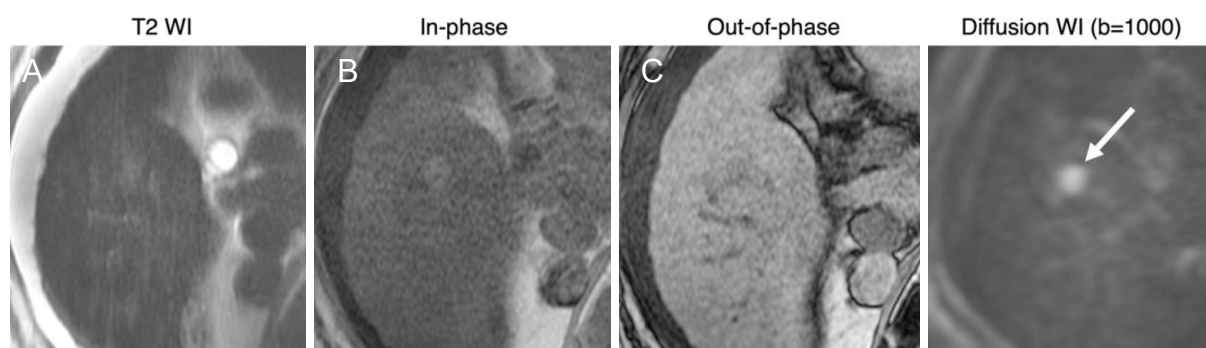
Positive NC-AMRI examinations: 66-year-old male with HCV cirrhosis. Images show a 14 mm observation in seen in the right lobe. While subtle on T2WI (A) and T1WI (B, C), the presence of restricted diffusion (arrow) favors malignancy. HCV: hepatitis C virus; NC AMRI: non-contrast abbreviated magnetic resonance imaging
